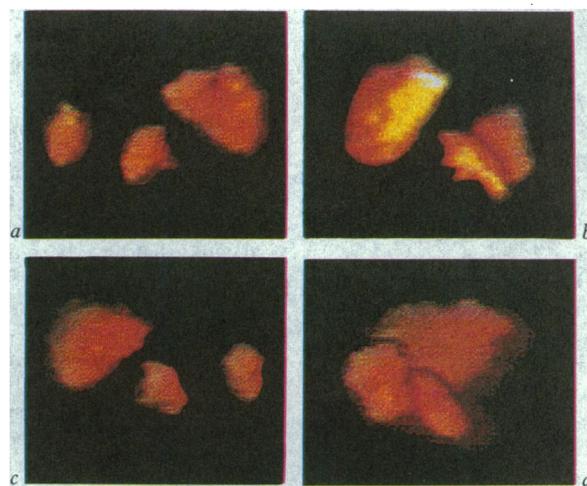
Scan with serum amyloid P component labelled with ¹²⁵I. Single photon emission computed tomograms have been reconstructed as rotating three dimensional image. Four enhanced images show spleen and adrenal glands (which seem to be considerably enlarged) at 90° intervals through a single clockwise rotation at (a) 0°, (b) 90°, (c) 180°, and (d) 270°
